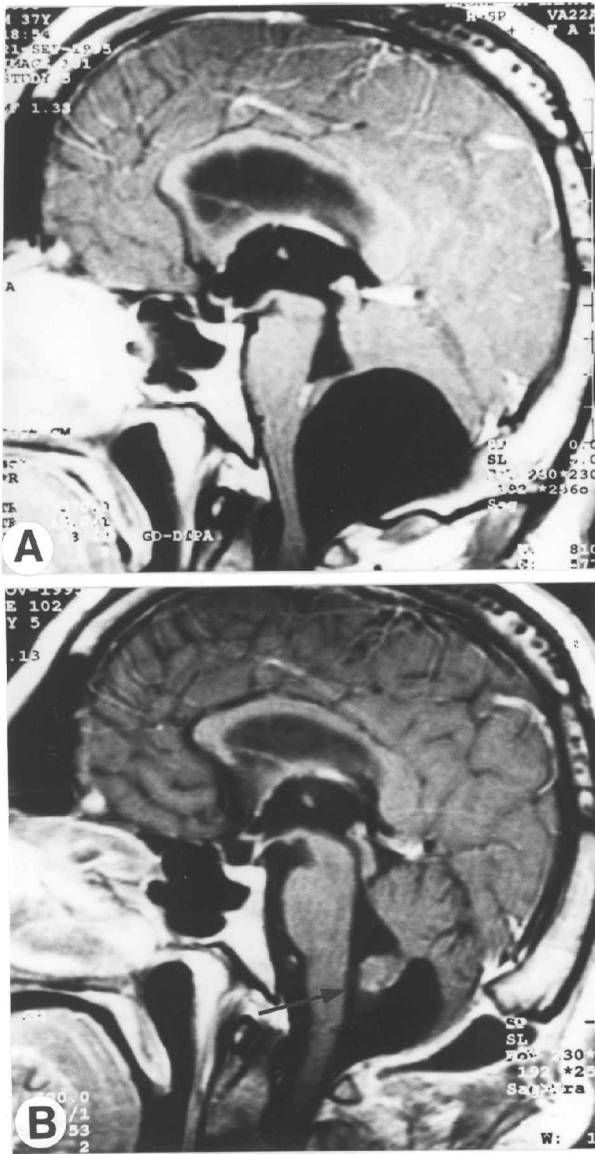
Case 8. (A) Preoperative T1-weighted mid-sagittal MRI scan shows a retrocerebellar arachnoid cyst compressing the fourth ventricle. There was no elevation of the torcula and no enlargement of the posterior fossa. (B) After cyst wall excision and fenestration into the fourth ventricle, the cyst has decreased in size. The communication established between the cyst and the fourth ventricle is seen (arrow).
